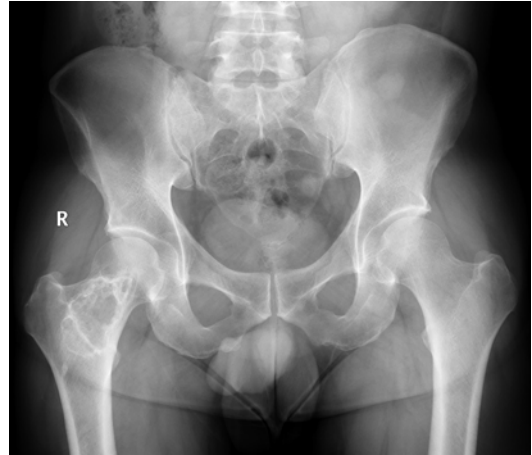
Plain radiograph showing a latent cystic bone lesion of the right femoral neck surrounded by a thick sclerotic rim
